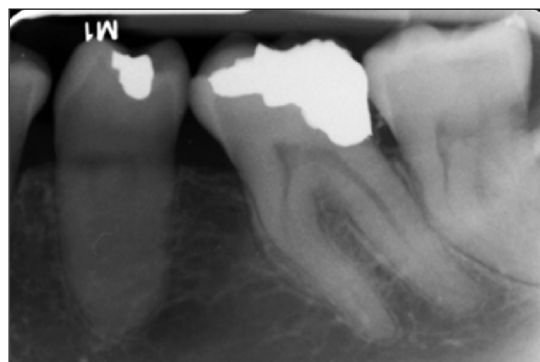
Radiographic image of the corrected restoration.
